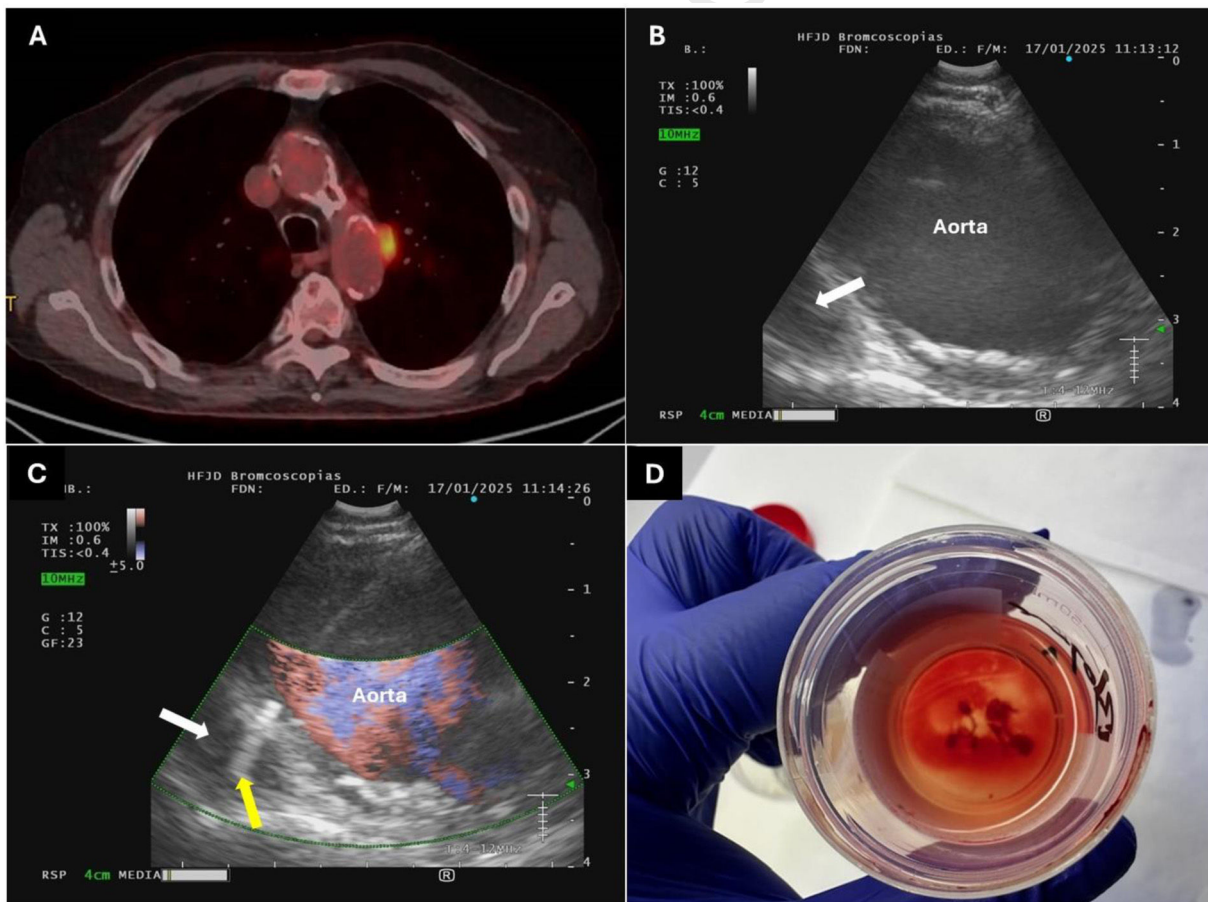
(A) 18FDG PET-CT, hypermetabolic para-aortic adenopathy. (B) EUS-B, transesophageal approach, aorta and para-aortic adenopathy (white arrow). (C) EUS-B-TVNA through aortic artery shown with color Doppler, 21G needle (yellow arrow), para-aortic adenopathy (white arrow). (D) Cell blocks obtained.
